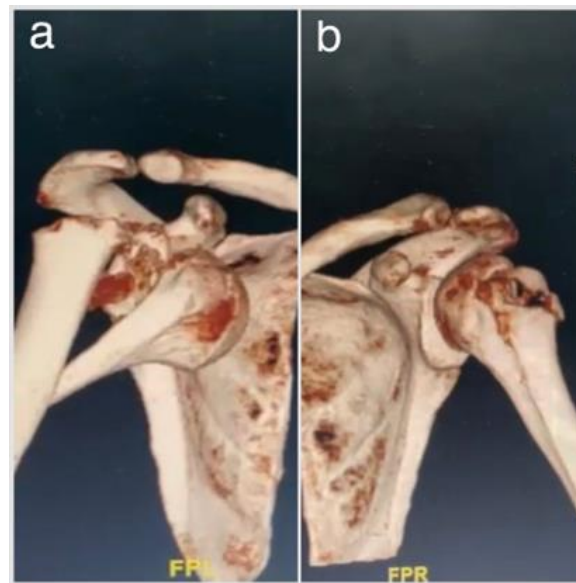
CT with 3D reconstruction of the (a) right shoulder and (b) left shoulder.
